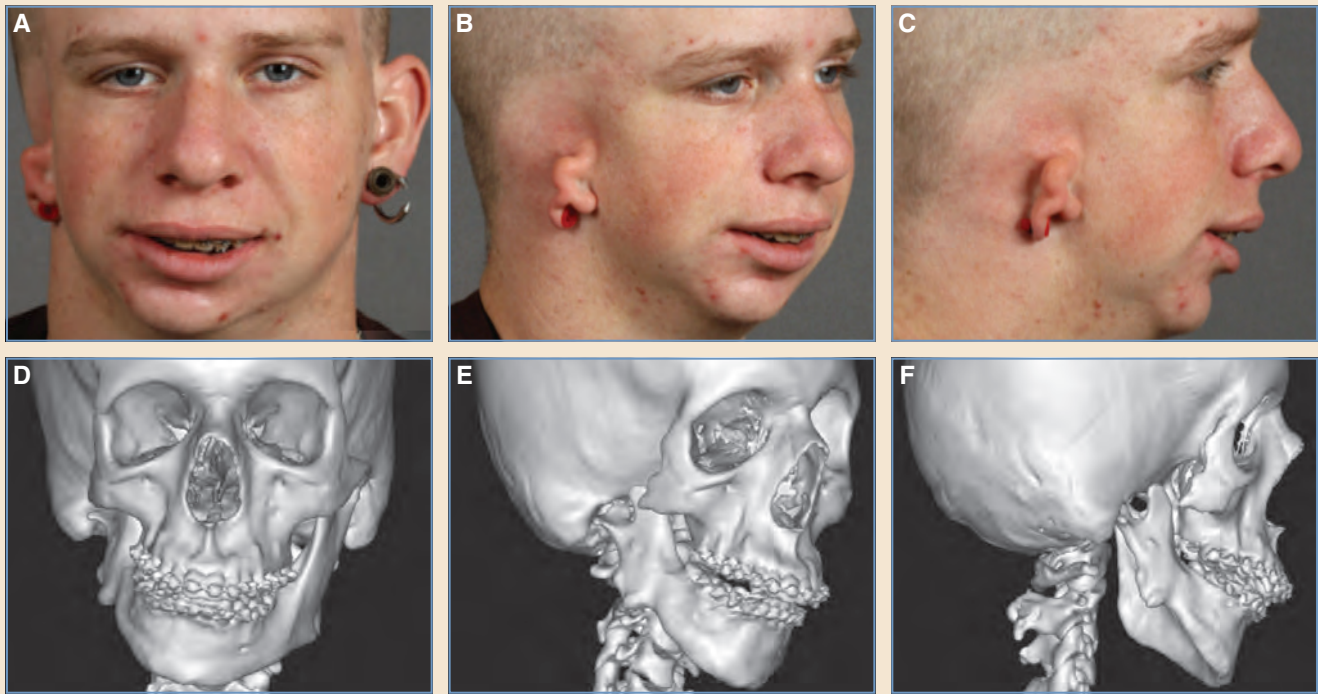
This patient had right CFM (Kaban-Pruzansky type IIB). A-F, Preoperative clinical images and CT scans showed the underlying skeletal anatomy.
